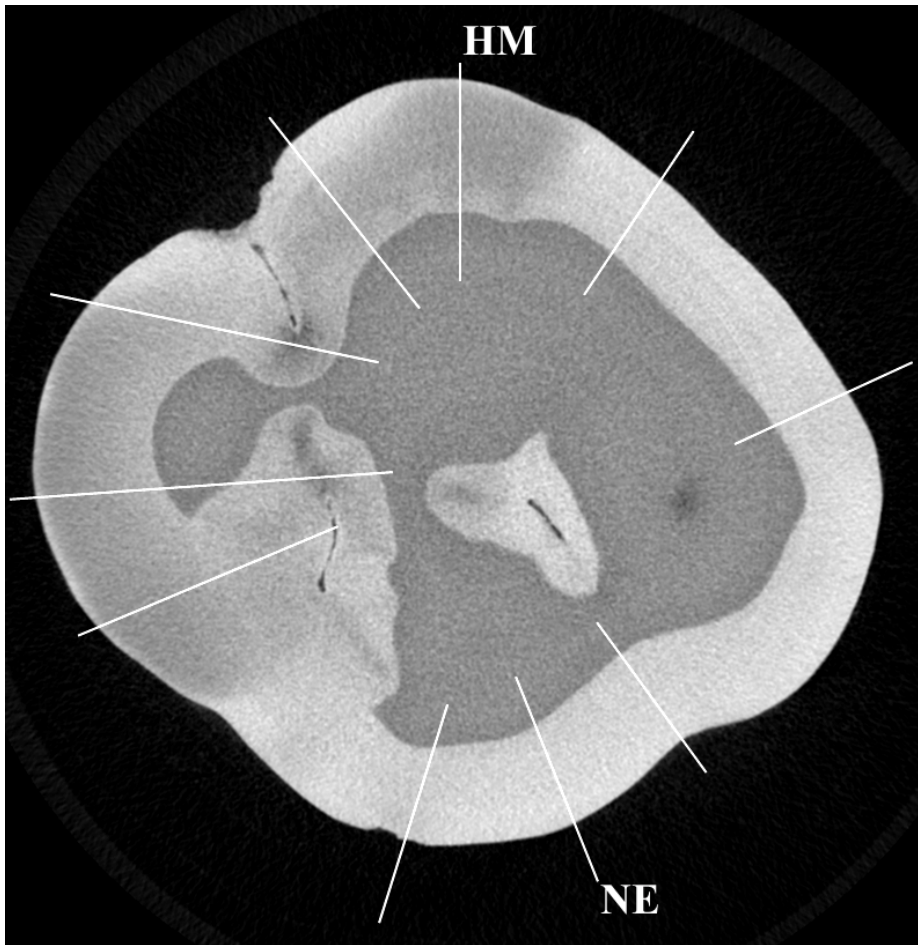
Example of a 3D X-ray micro-computed tomography image of an MIH tooth. The more compact areas represent hypomineralized enamel.
